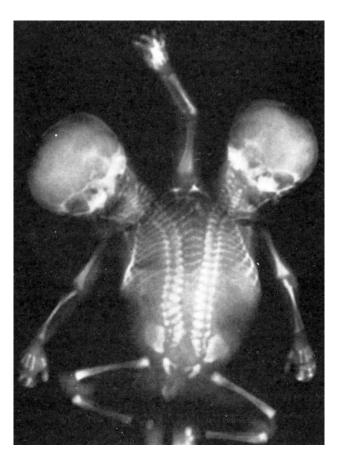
Dicephalus dipus tribrachius. X-ray of skeleton showing common arm with fused humerus and three bones in the forearm. Reproduced with permission from reference 3
